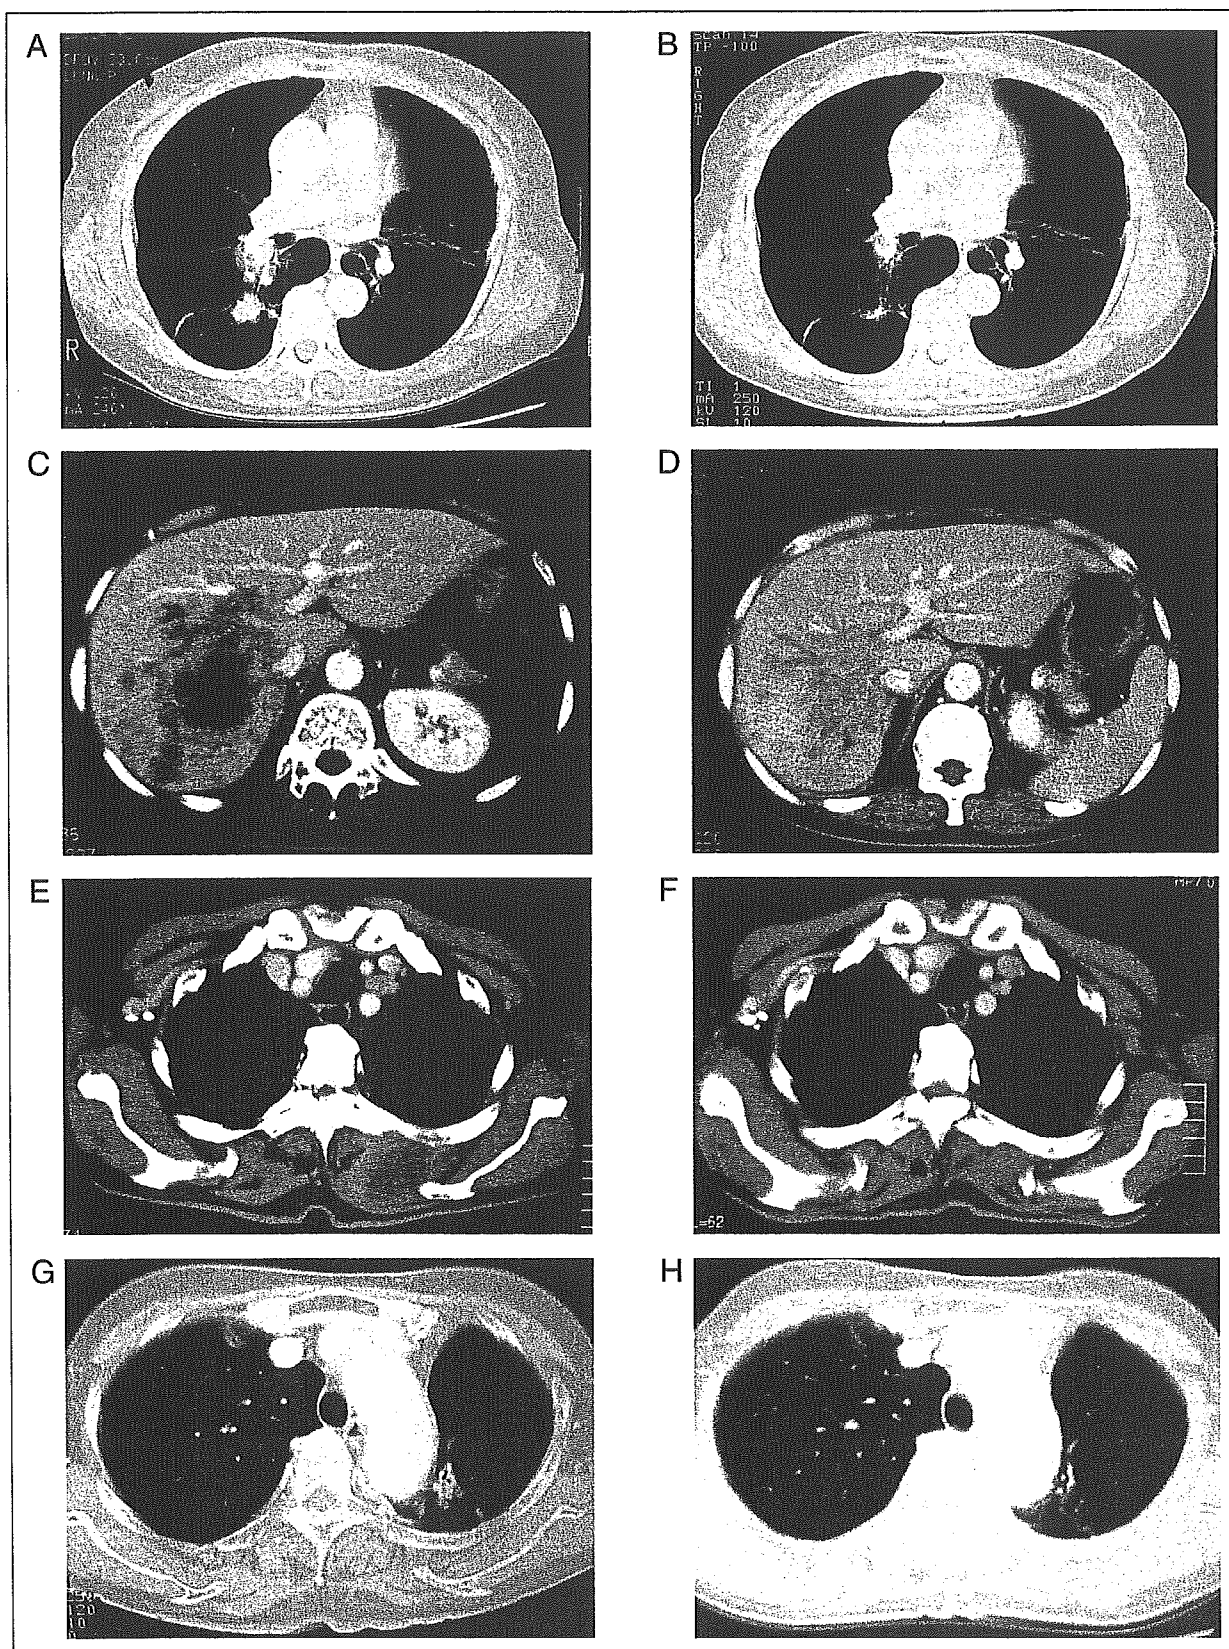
Examples of the response to gefitinib in representative four patients with recurrent non-small-cell lung cancer. Computed tomography (CT) scans before gefitinib treatment (A, C, E, G) and after the gefitinib was initiated (B, D, F, H) are shown. CT scans of patient L703 (A, B), patient L1492 (C, D), patient L1362 (E, F), and patient L1171 (G, H).
